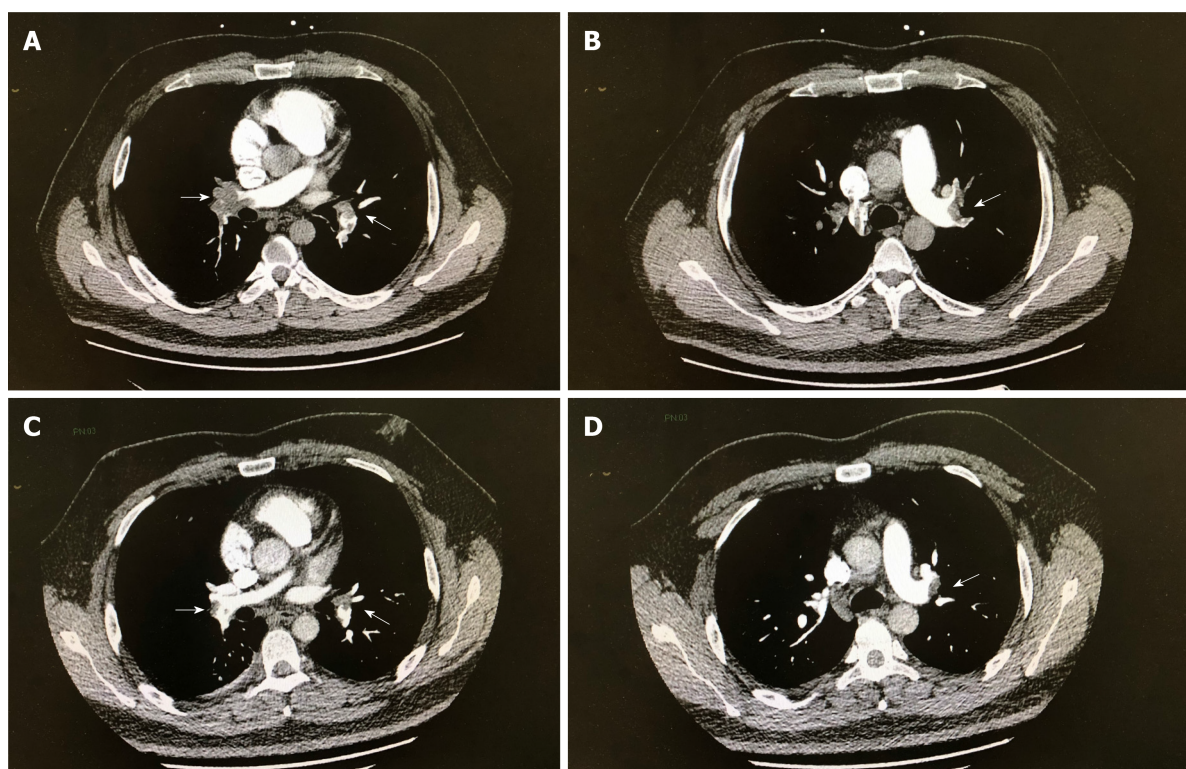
Computed tomographic pulmonary angiography images. A and B (before thrombolysis): The diameter of the left and right pulmonary artery trunks was increased, and there were multiple large filling defects; C and D (5 d after thrombolysis): The extent of filling defect was significantly obviously reduced.
